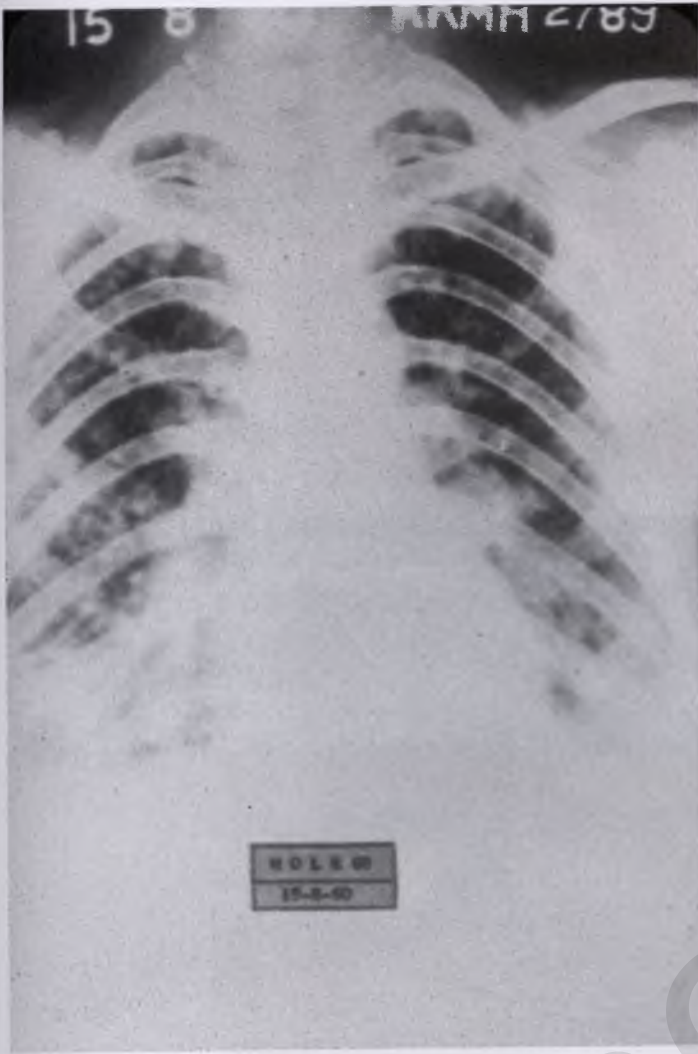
Metastatic choriocarcinoma with miliary pattern on radiograph.
